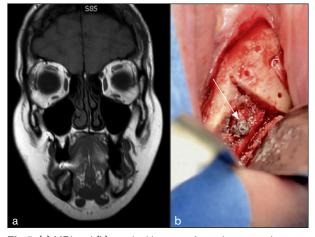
(a) MRI and (b) surgical images of a patient reporting neuropathic pain after a dental implant placement procedure. There was no clear visualization of the trauma on MRI (T1-TSE sequence), but during surgery, contact between the implant screw and the inferior alveolar nerve was seen (arrow).
